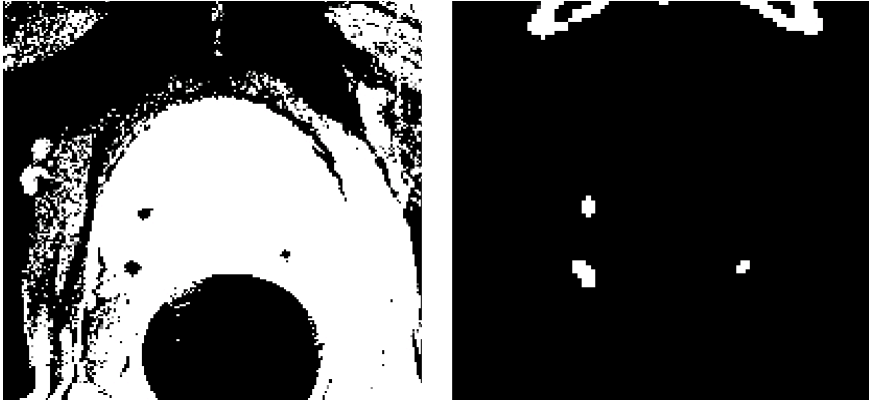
An MRI and a CT slice of the prostate after thresholding, where three markers are clearly visible.
